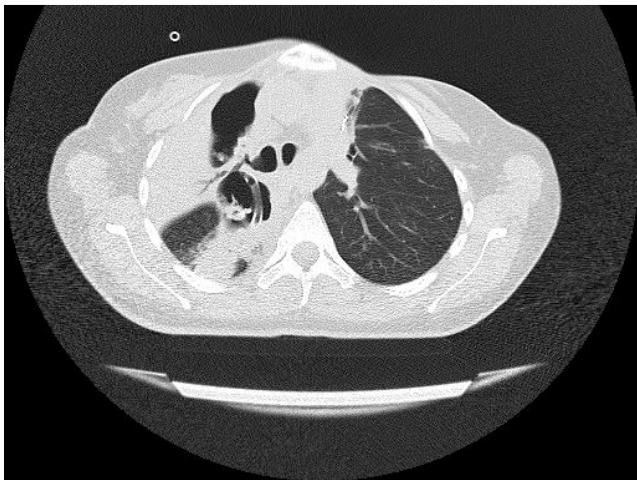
Computed tomography (CT) scans showed a large cavity in right upper lobe.
